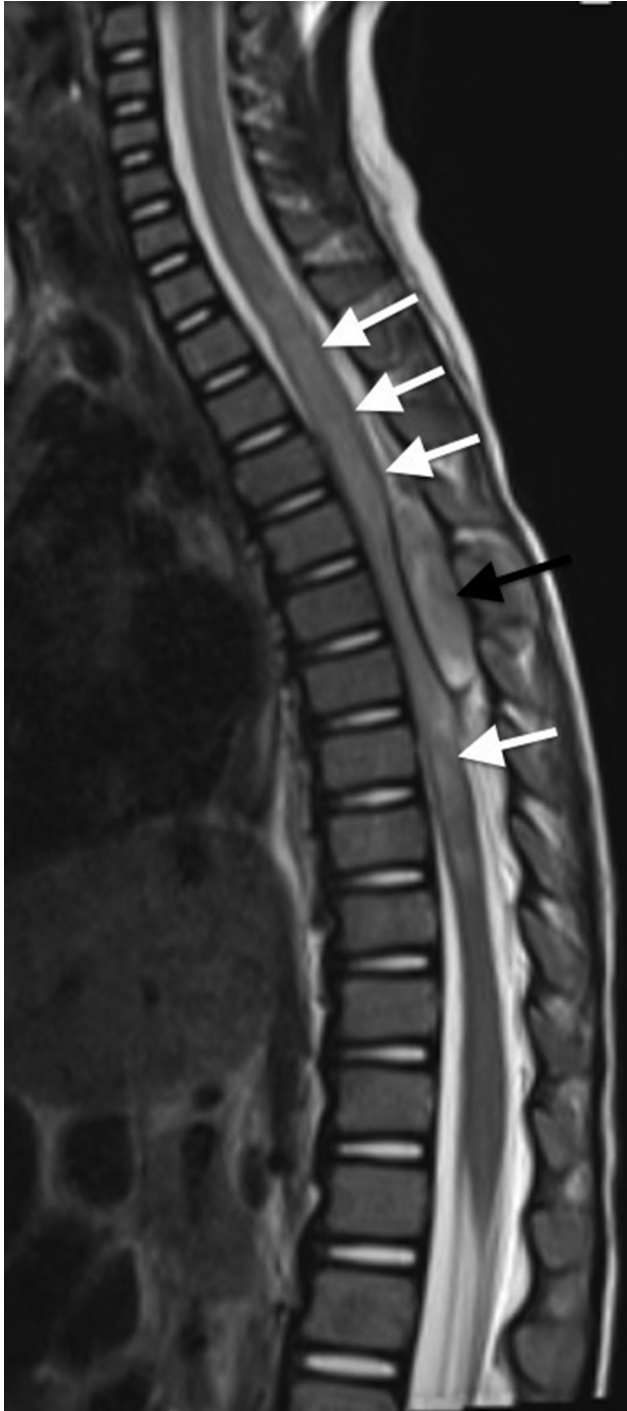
The lesion was heterogenous and hyperintense on T2-weighted magnetic resonance image (black arrow), and the spinal cord had vasogenic edema at the level of T1–T8 (white arrows).
